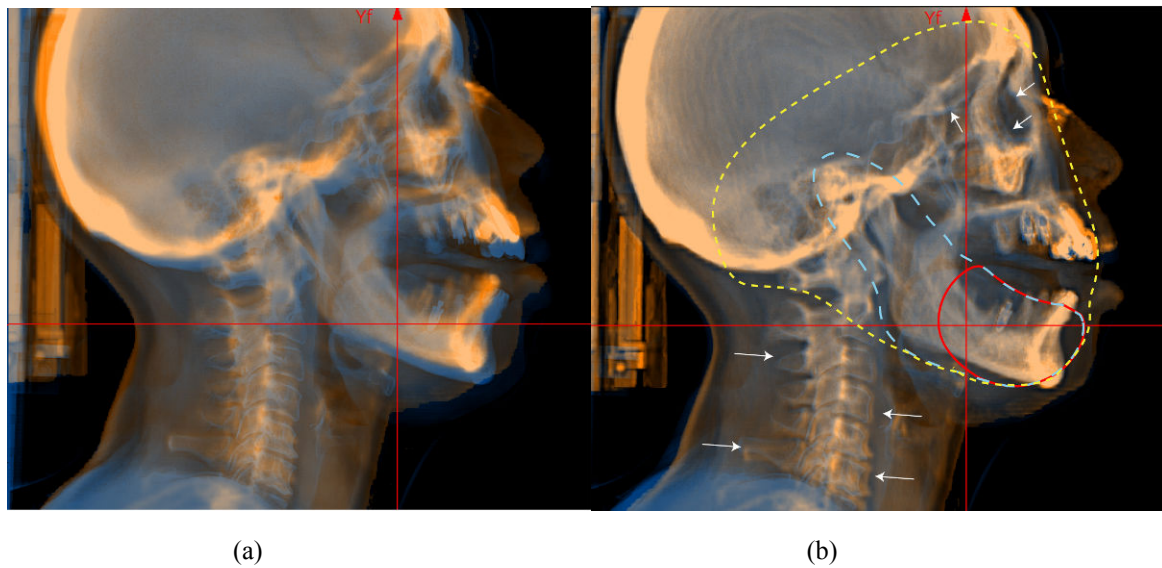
FPD images (blue layer) overlaid on DRR images (orange layer) (a) before registration and (b) after registration. White arrows marked in lower panels are positional errors which differ from the referenced DRR images. Yellow and blue dotted lines and the reference solid line show large, middle and small ROI regions. Registration parameters were a computation grid of 2 mm, CT slice thickness of 2 mm, middle ROI, and image processing on.
